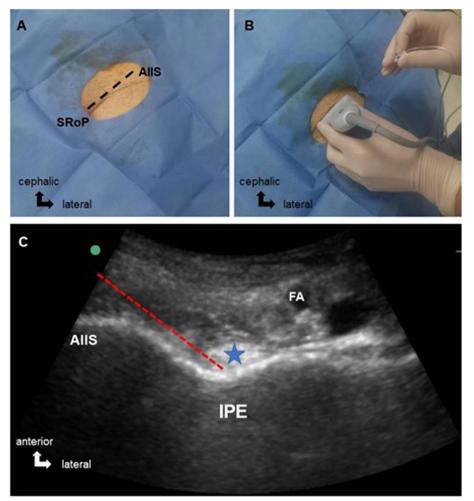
Images of an ultrasound-guided pericapsular nerve group block. A The left hip in the supine position. B Orientation of the ultrasound probe. C The needle tip was positioned between the psoas tendon and the pubic ramus by using an in-plan approach. AllS, anterior inferior iliac spine; FA, femoral artery; IPE, iliopubic eminence; SRoP, superior ramus of pubis; PT, psoas tendon
